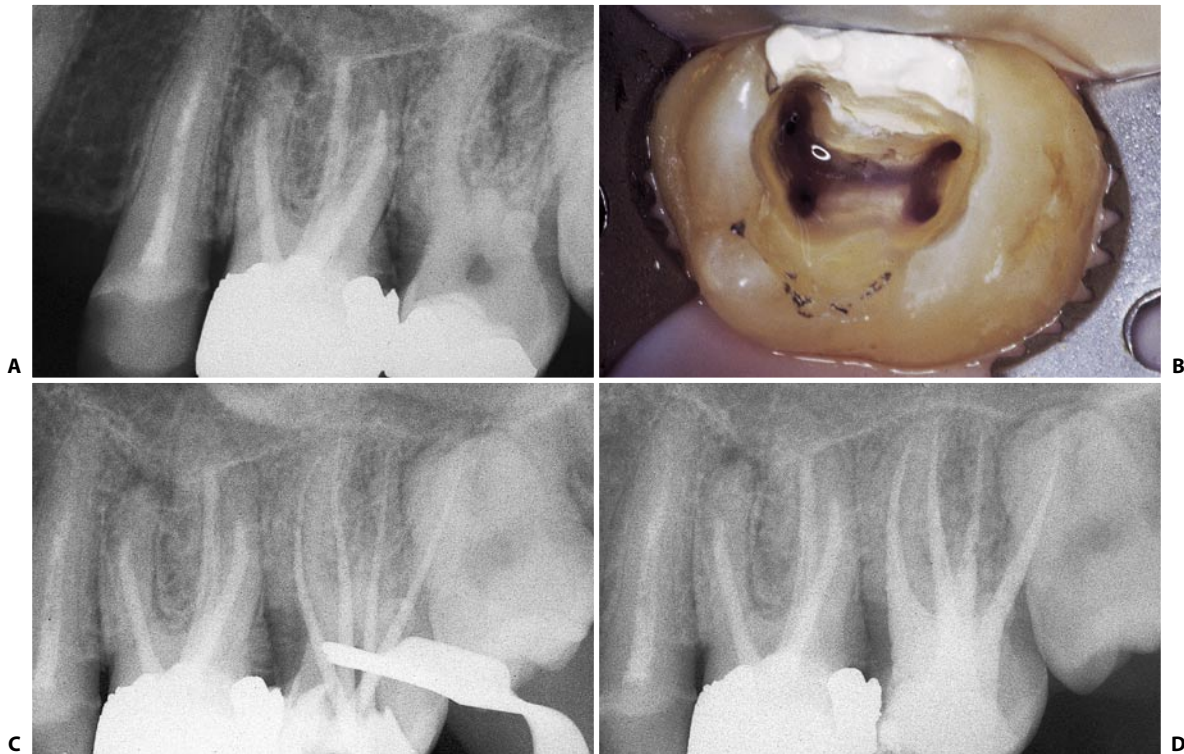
An upper left second molar with two palatal canals in two separate roots. A. Preoperative radiograph. B. Access cavity. C. Intraoperative radiograph. D. Postoperative radiograph.
